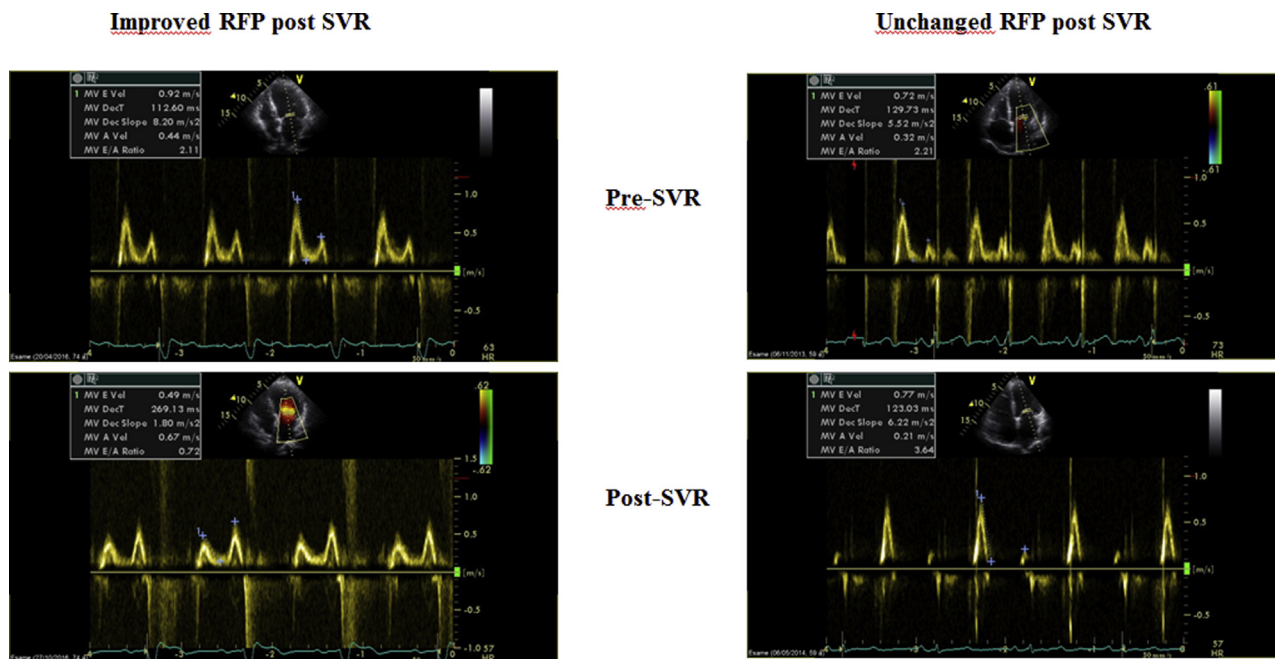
Doppler diastolic mitral flow tracing in 2 cases of ischemic cardiomyopathy with a restrictive filling pattern (RFP; E/A ratio ≥ 2): before surgical ventricular restoration SVR (pre-SVR) (top) and after SVR (post-SVR) (bottom). (Left) Improved diastolic mitral flow (E/A ratio = 0.72); (right) persistent RFP (E/A ratio = 3.64).
